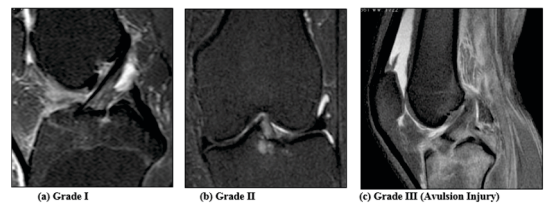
PDFS Sagittal (a. & c.) & STIR coronal (b.) MRI images showing grades of ACL injury respectively
